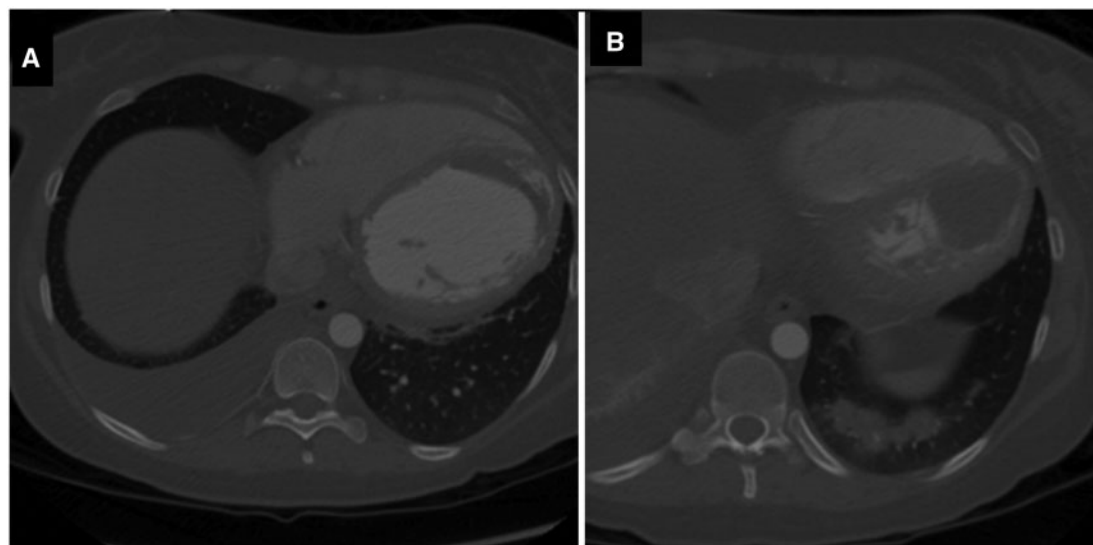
Axial images by computed tomography, acquired at two different levels (A, B) after administration of iodinated contrast agent. Hypodense masses without contrast uptake can be seen filling left ventricular cavity.
